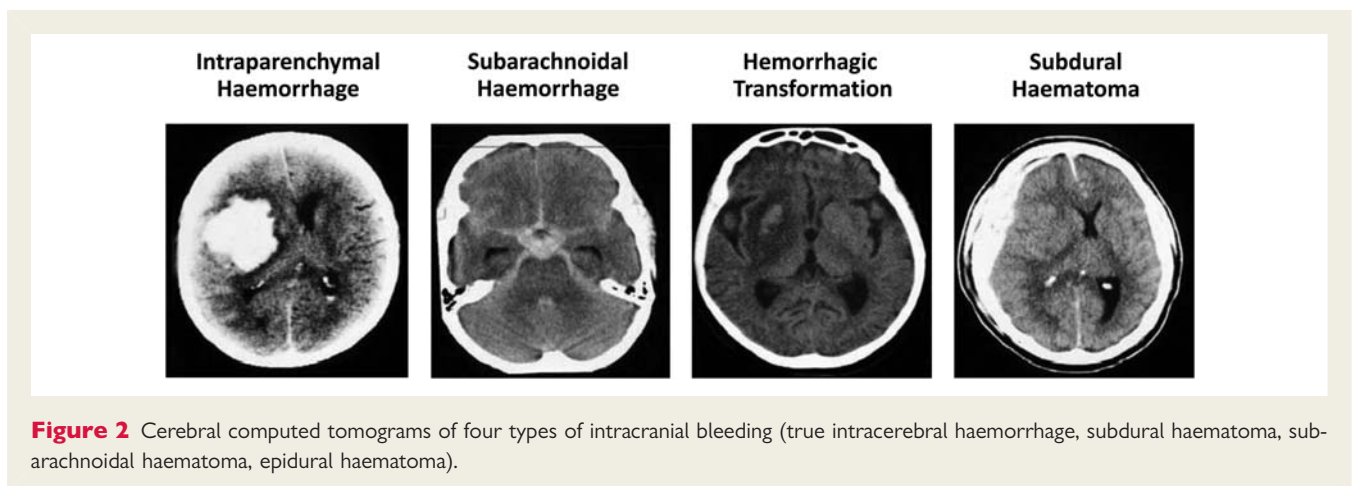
Cerebral computed tomograms of four types of intracranial bleeding (true intracerebral haemorrhage, subdural haematoma, subarachnoid haematoma, epidural haematoma).
